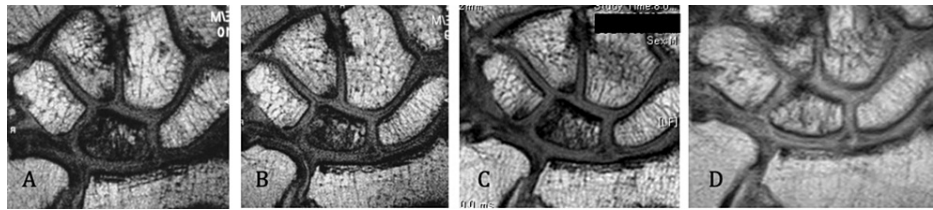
Chronological change in the postoperative MRI results of a 41-year-old man before and after surgery for Kienböck's disease
